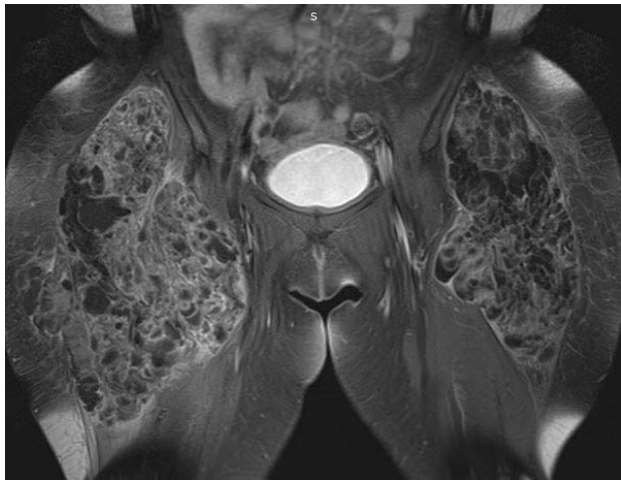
MRI axial T2WI showing bilateral large areas of calcification returning low signals in proximal thighs along the lateral aspect of hip joints
